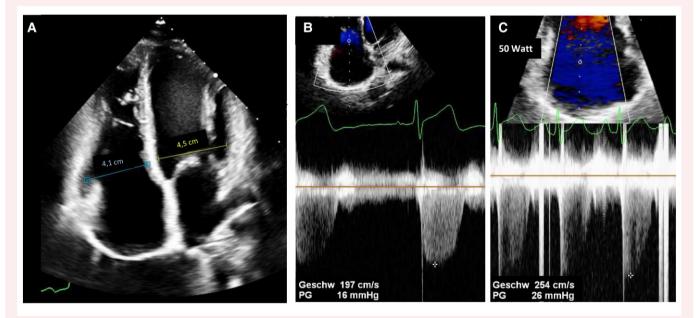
Transthoracic echocardiography post-atrial septal defect closure. Two-dimensional (A), spectral Doppler at rest (B), and exercise (50 W, C) transthoracic echocardiography.
